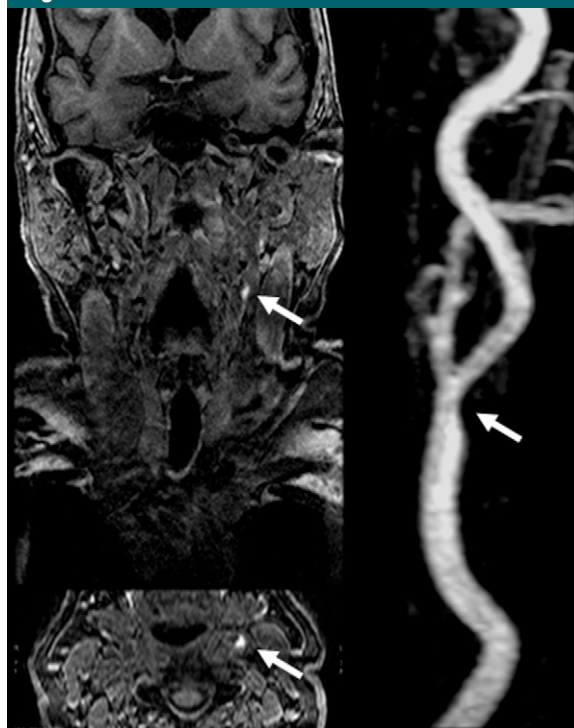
(Top left) Coronal and (bottom left) axial MR images depicting IPH in 73-year-old woman show high signal intensity in the left carotid artery (arrows). Right: MR angiogram of left carotid artery (arrow) in same patient.
